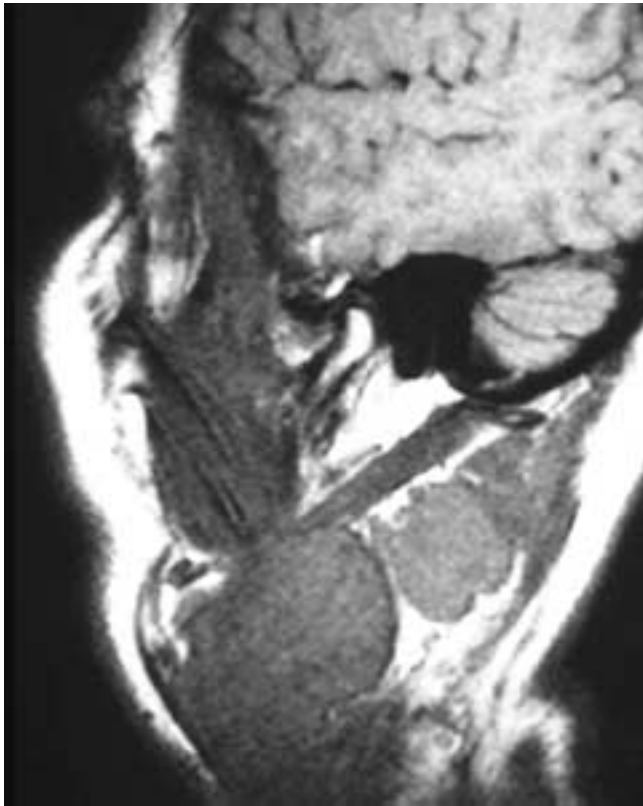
Sagittal T1-weighted MR image shows multiple homogeneous, grossly enlarged lymph nodes with no involvement of the adjacent fat planes. This patient had large cell lymphoma.
